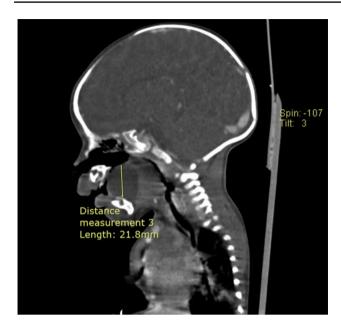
CT scan showing the cystic lesion involving the base of the tongue
